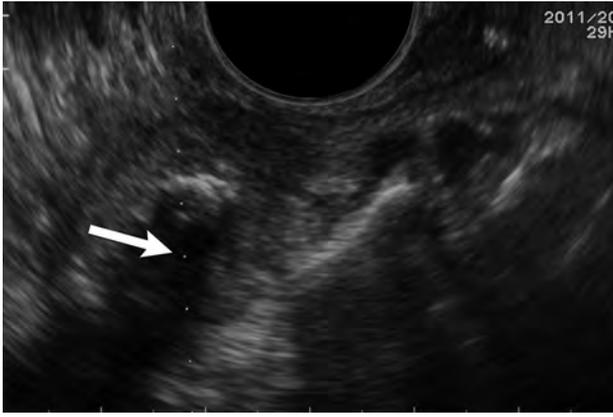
Biopsy line. Transverse sonography before biopsy of a partially calcified right retropharyngeal mass demonstrates a biopsy line and expected path of the biopsy needle through the lesion (white arrow).
